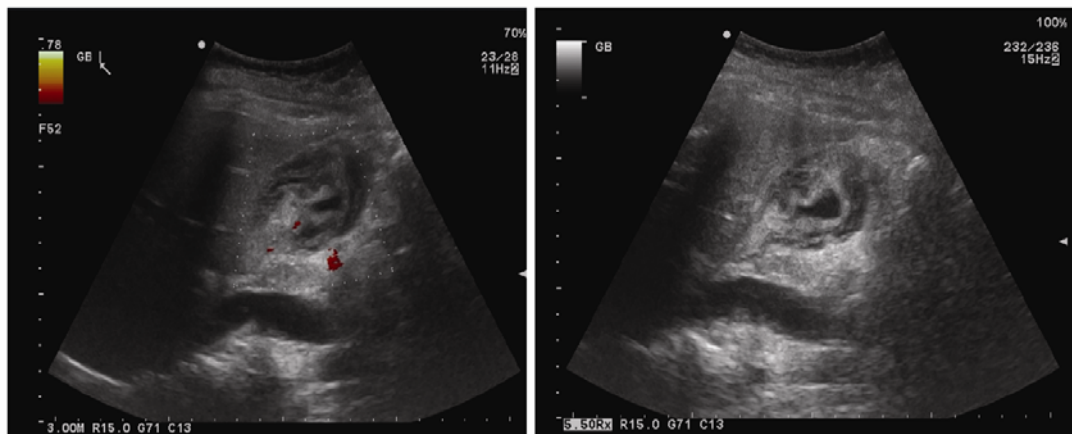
Ultrasound of the gallbladder showing a thickened gallbladder wall and sludge within the lumen
